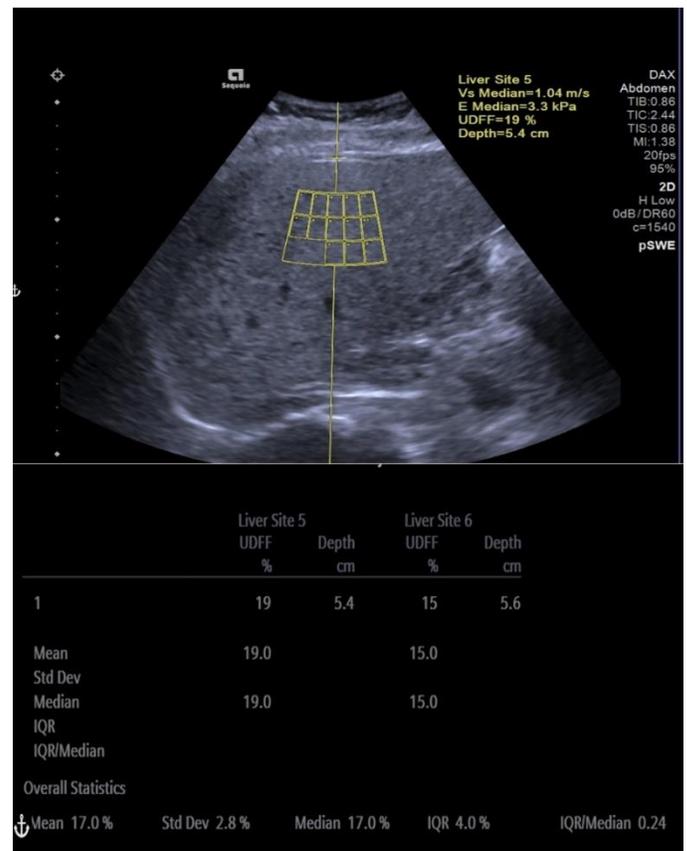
Ultrasound-Derived Fat Fraction (UDFF) scan showing hepatic steatosis.
